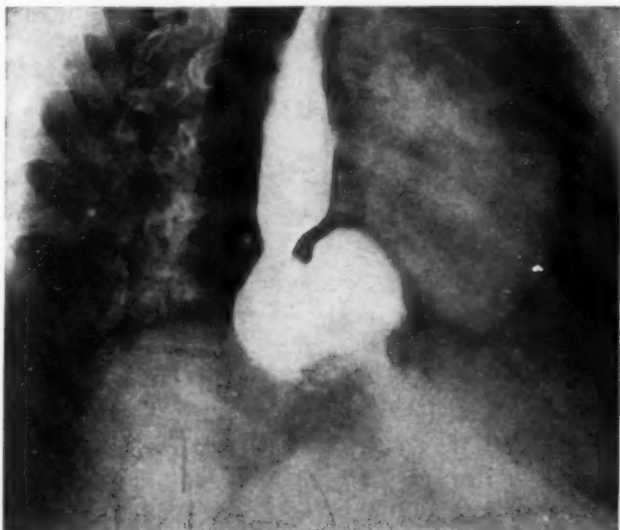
Large hiatal hernia observed in a woman 67 years of age. The entire esophagus appeared greatly dilated, but this might have been the result of shortening of the esophagus itself. While the roentgen film exhibited no narrowing at the esophagogastric junction, at esophagoscopy there was a marked redundancy of folds in this locality making it difficult to introduce the esophagoscope into the stomach. Roentgenograms revealed not only marked widening of the esophageal lumen and displacement of a great part of the stomach into the thorax but also very marked dilatation of the opening in the diaphragm.
